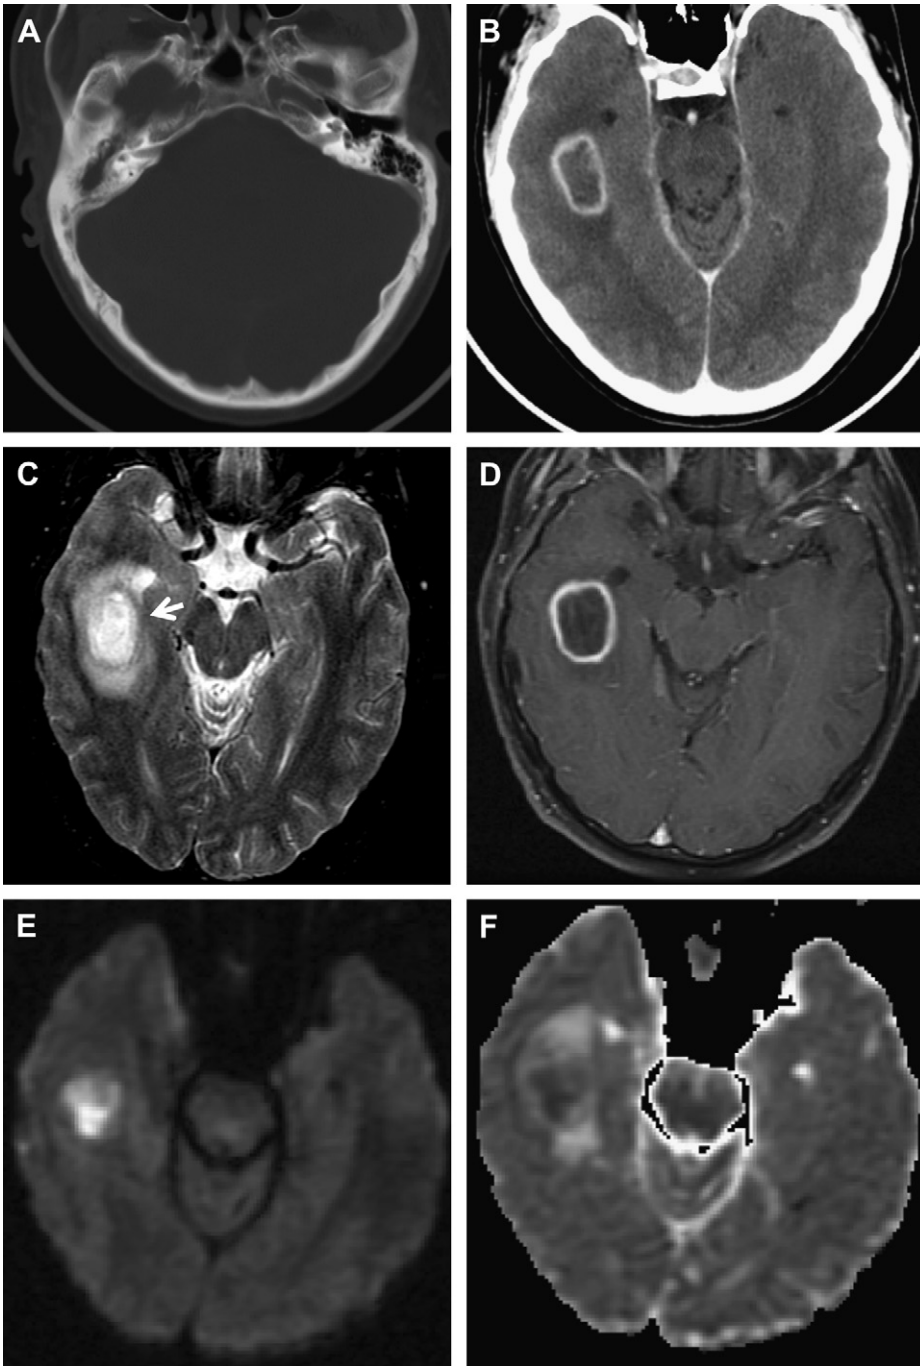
A patient who presented with ear infection and headache. (A) CT bone window demonstrates complete opacification of the right middle ear cleft and poorly pneumatized right mastoid, consistent with chronic right otomastoiditis. (B) On contrast-enhanced CT there is an associated ovoid ring-enhancing mass in the right temporal lobe with surrounding vasogenic edema. (C) On axial T2-weighted sequence, it has central hyperintense signal corresponding to the pus cavity and the characteristic surrounding T2 hypointense signal of the abscess capsule (*white arrow*). Local mass effect results in entrapment of the adjacent mildly dilated right temporal horn. (D) Axial T1 postcontrast sequence demonstrates typical smooth ring enhancement of a mature abscess. (E, F) Corresponding diffusion-weighted sequence and apparent diffusion coefficient (ADC) maps confirm restricted diffusion within the abscess cavity.
